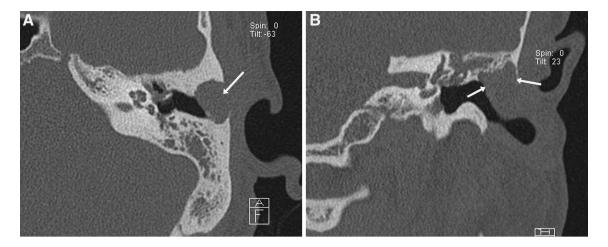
EAC cholesteatoma. Axial (a) and coronal (b) CT images show a lobulated opacity causing pressure erosion of the adjacent bony margins of the EAC (arrows)
